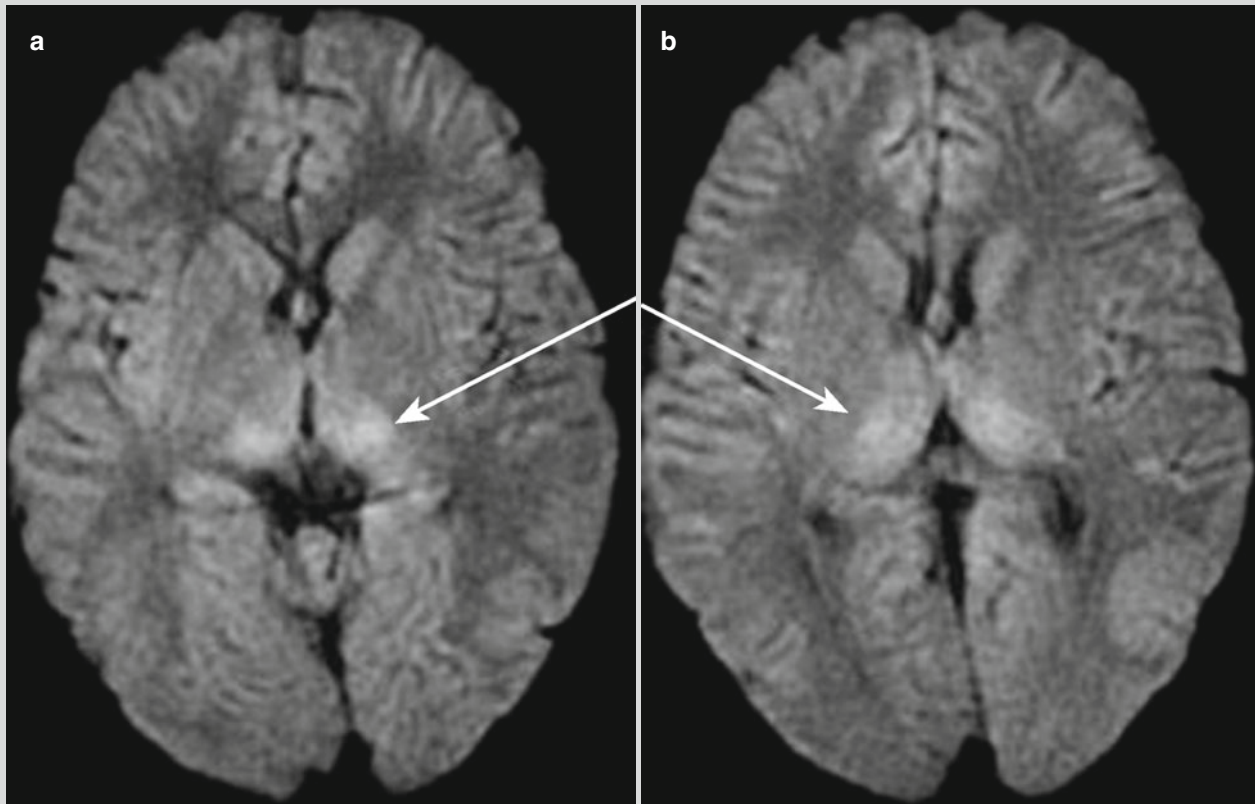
Reye syndrome. (a, b) MR imaging of T1WI, T2WI, and FLAIR demonstrates no abnormality, while DWI demonstrates symmetrical limited diffusion at bilateral thalamus (indicated by arrows) (Reproduced with permission from Johnsen and Bird *Pediatr Neurol*, 2006, 34 (5): 405)
